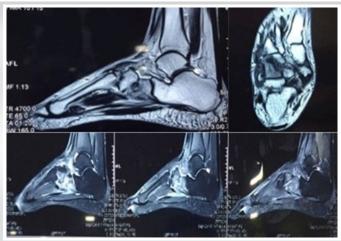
Hyperintensity noted in navicular, cuboid, and medial cuneiform bones on short-tau inversion-recovery sequence of magnetic resonance imaging suggestive of tissue edema and probable infective pathology.
